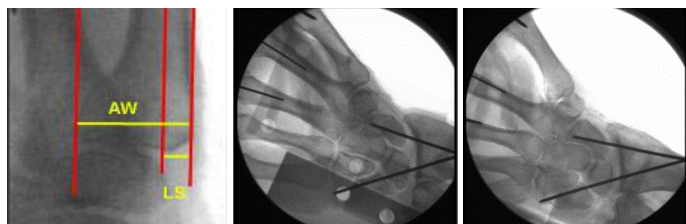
Left: Percent subluxation during key pinch calculated as lateral subluxation (LS) divided by the metacarpal articular width (AW). Red lines parallel to the metacarpal long axis. Mid: Typical AP (0°) X-ray. Right: Typical X-ray 25° supination.
